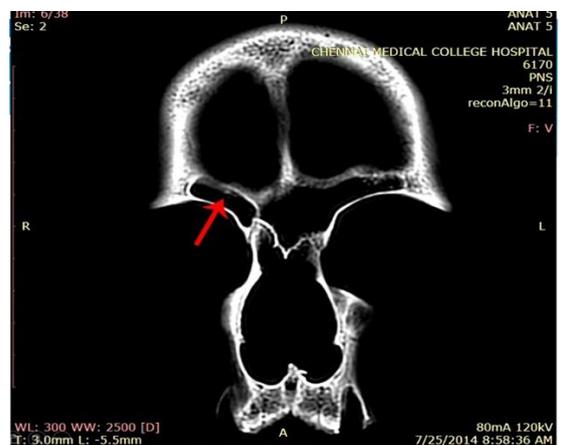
Coronal CT of incomplete metopic skull showing asymmetrical frontal sinuses with small right sinus
